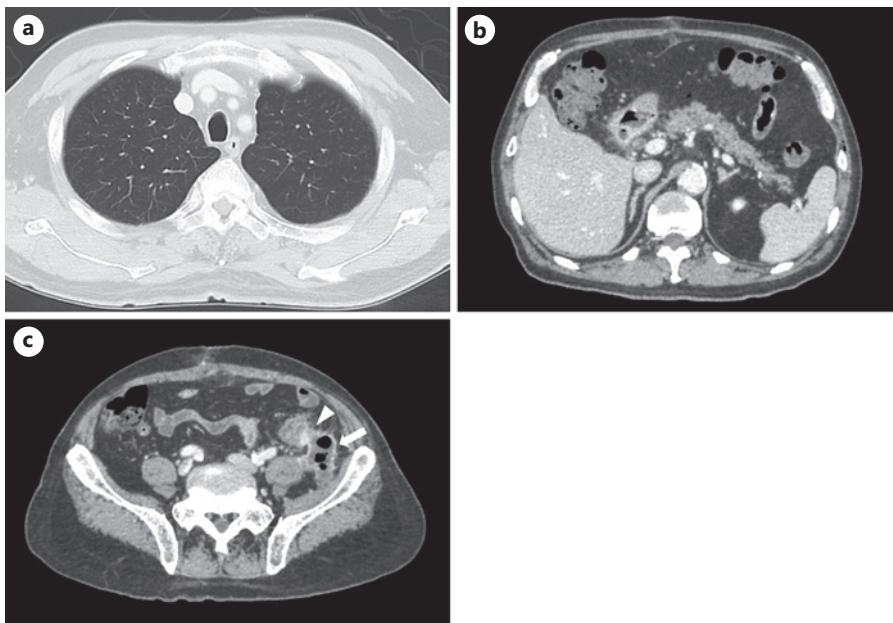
Computed tomography on postoperative day 23 shows resolution of the mediastinal emphysema (a), resolution of the retroperitoneal emphysema around the pancreas (b), and development of localized fluid and air collections in the retroperitoneum, contiguous with the descending colon (c). Arrow: area of the fluid and air collections in the retroperitoneum. Arrowhead: area of the continuity with the descending colon and fluid and air collections in the retroperitoneum.
